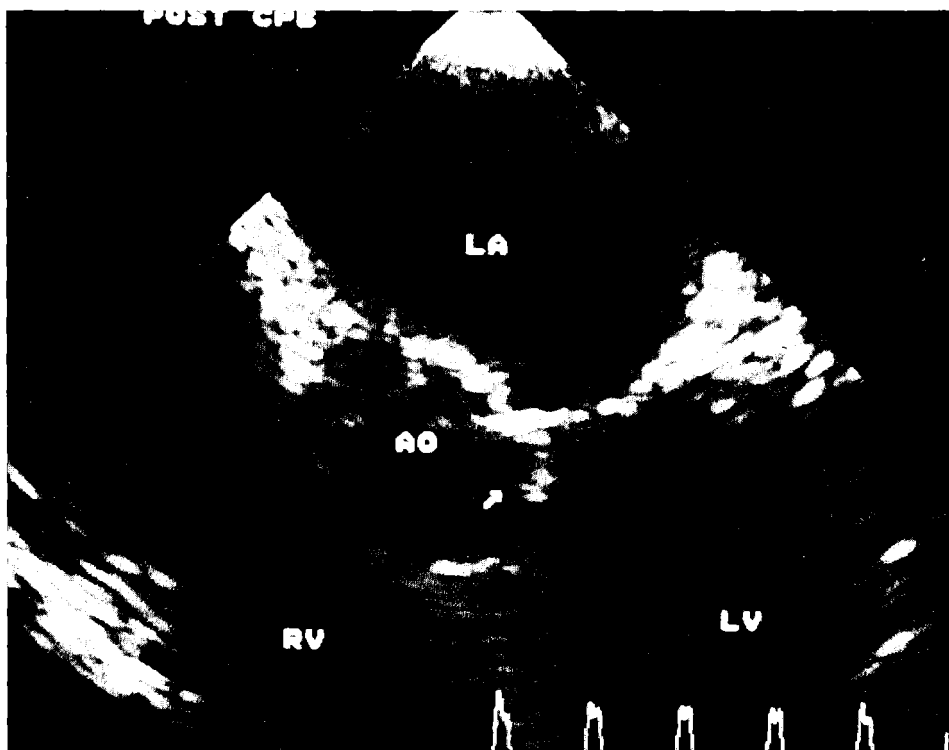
Immediate post bypass transoesophageal study revealing a remnant of a discrete fibromuscular membrane attached to the mid portion of the anterior leaflet of the mitral valve (arrow).
